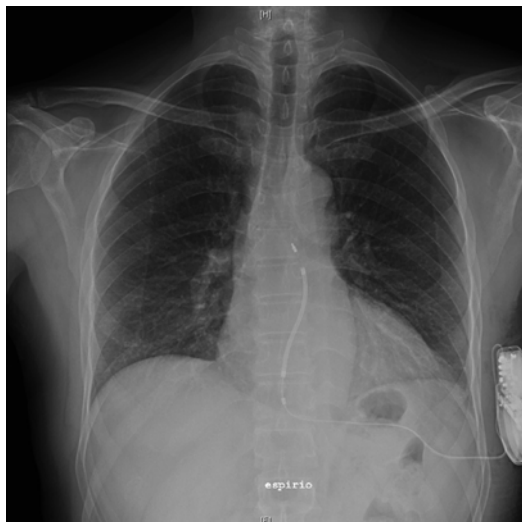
Chest X-ray anterior-posterior (AP) projection
